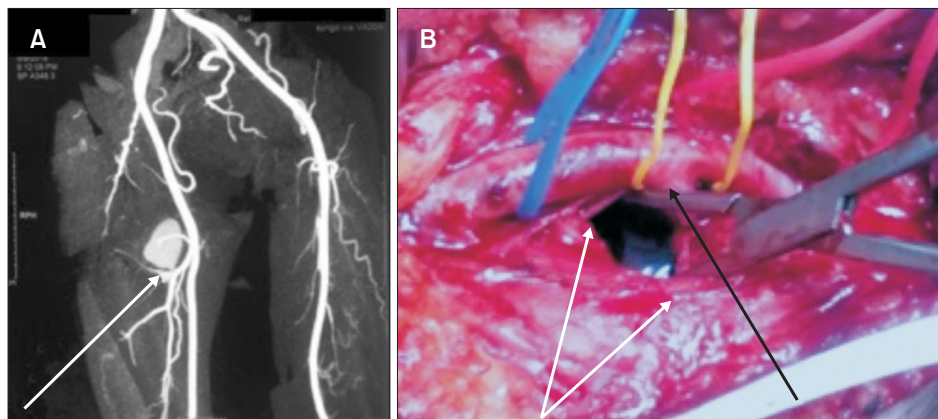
(A) Computed tomography angiography with contrast showed a right deep femoral artery (DFA) aneurysm. The arrow indicates pseudoaneurysm originated from the DFA. (B) Operative image showed the DFA pseudoaneurysm with the underneath femoral nerve. The white arrows indicate branches of the femoral nerve stretched by the pseudoaneurysm (post decompression) and the black arrow indicates DFA.
